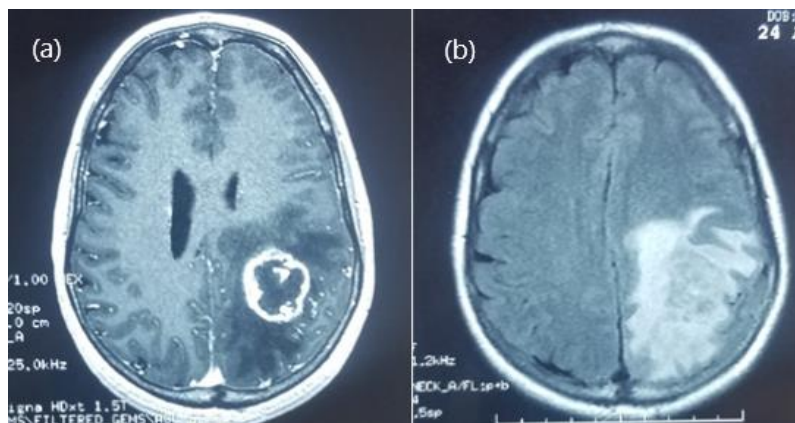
Axial T1-weighted contrast-enhanced (a) and Flair (b) MRI showing a temporo-parietal mass with surrounding edema
